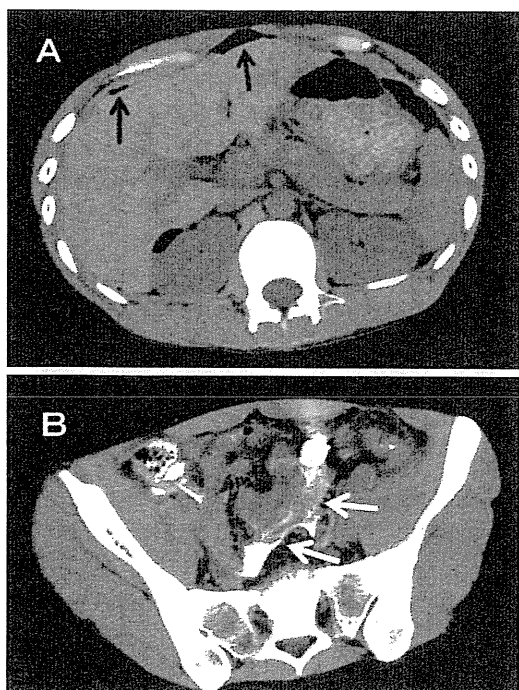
Enhanced computed tomography at the sigmoid colon perforation. Free air (*black arrows*) and stool containing barium (*white arrows*) were observed in the abdominal cavity
